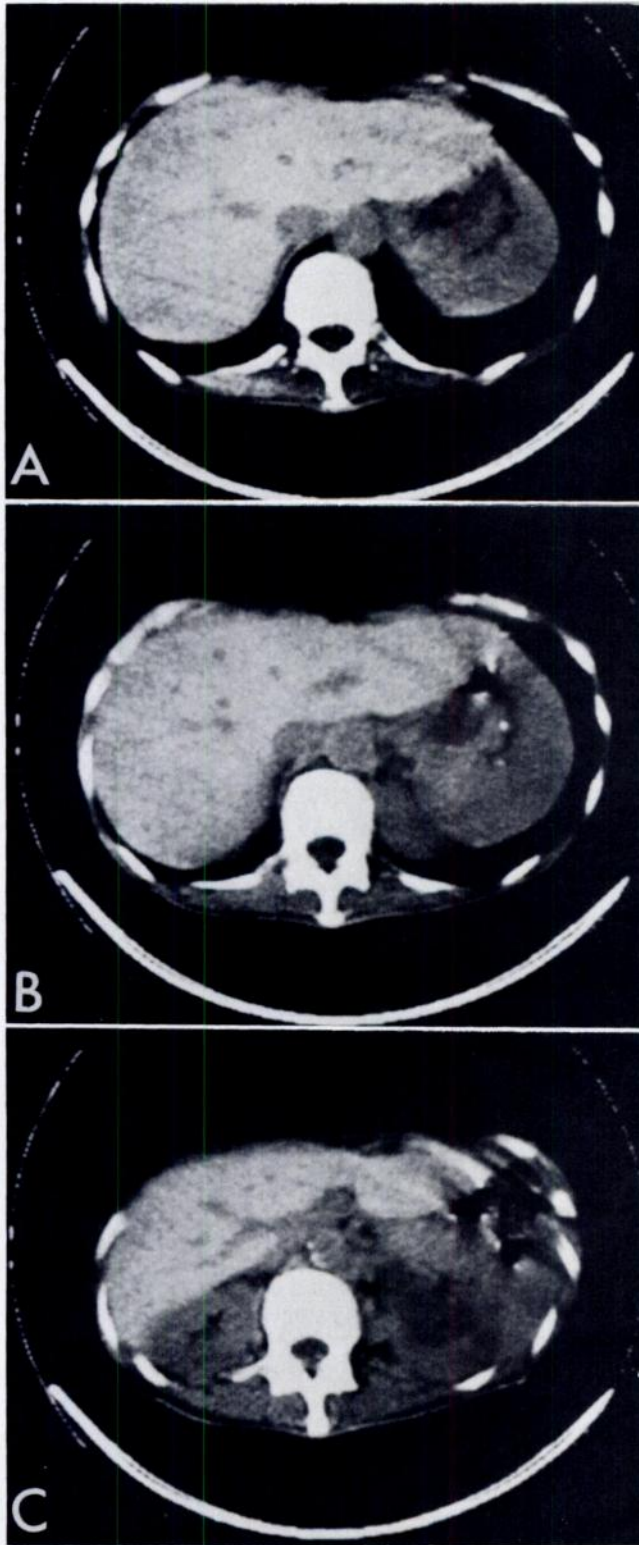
CT scans of normal liver with intrahepatic vessels. Portal tracts and vena cava are low density structures contrasting with higher density of parenchyma. In cross section (*A and B*), portal tracts are small round lucencies, but in left lobe (*B*) and toward hilum (*C*), linear and branching pattern is evident. Left kidney (*C*) is hydronephrotic because of distal ureteral obstruction.
